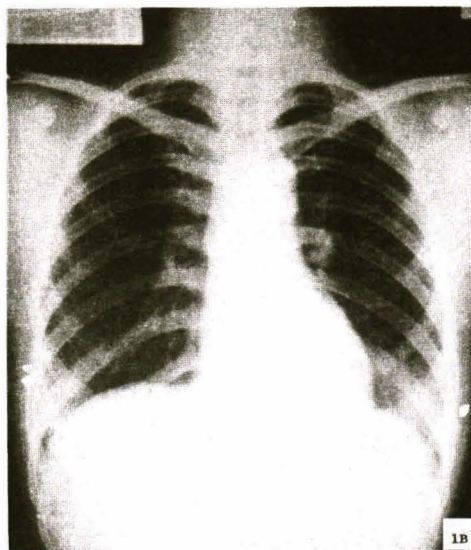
On the fourth hospital day after treatment, the follow-up chest radiography was essentially normal.
